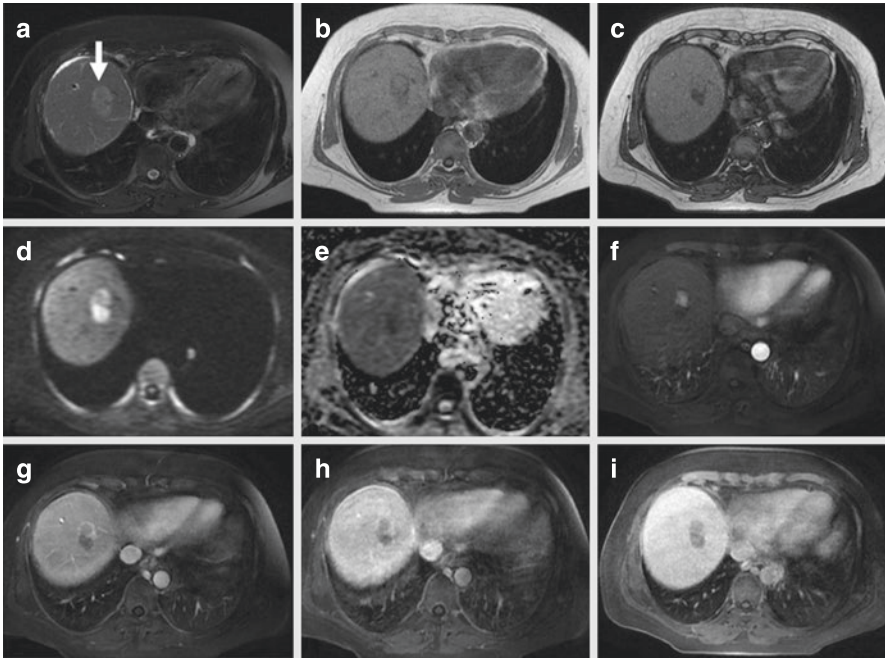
Small hepatocellular carcinoma nodule-in-nodule appearance. (a–c) A 3-cm nodule is appreciable on segment 8 (white arrow), mildly hyperintense on axial T2-weighted fat saturated (a), partially hyperintense on T1-weighted in-phase gradient echo (GRE) (b) with a partial signal drop-out on axial out-of-phase GRE (c) as expression intralesional fat. (d, e) Diffusion-weighted imaging (d), and apparent diffusion coefficient map (e) show lesion restriction related to hypercellularity. (f–i) Axial T1-weighted fat-saturated sequence in the arterial phase shows intense arterial wash-in of the upper portion of the nodule (f), with wash-out in the portal venous (g) and delayed (h) phases and lack of contrast agent uptake in the hepatobiliary phase (i). The figure is published with the patient’s authorization
